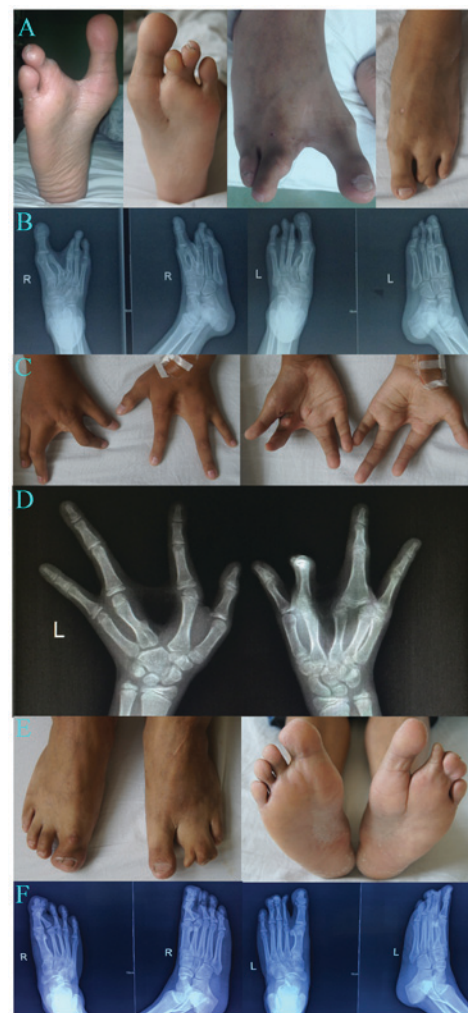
Clinical and X-ray images of patients from the split-hand/split-foot malformation 4 family. (A-D) The proband. (E and F) The father of the proband. L, left; R, right.
